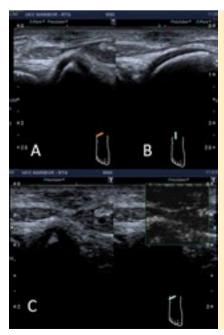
US of the right ankle. An additional subcutaneous mass demonwas strated terolaterally at the level of the talocrural joint (between blue markers) in the transverse (A) and sagittal (B) planes. Again, no vascularity was observed on Doppler examination (C).
